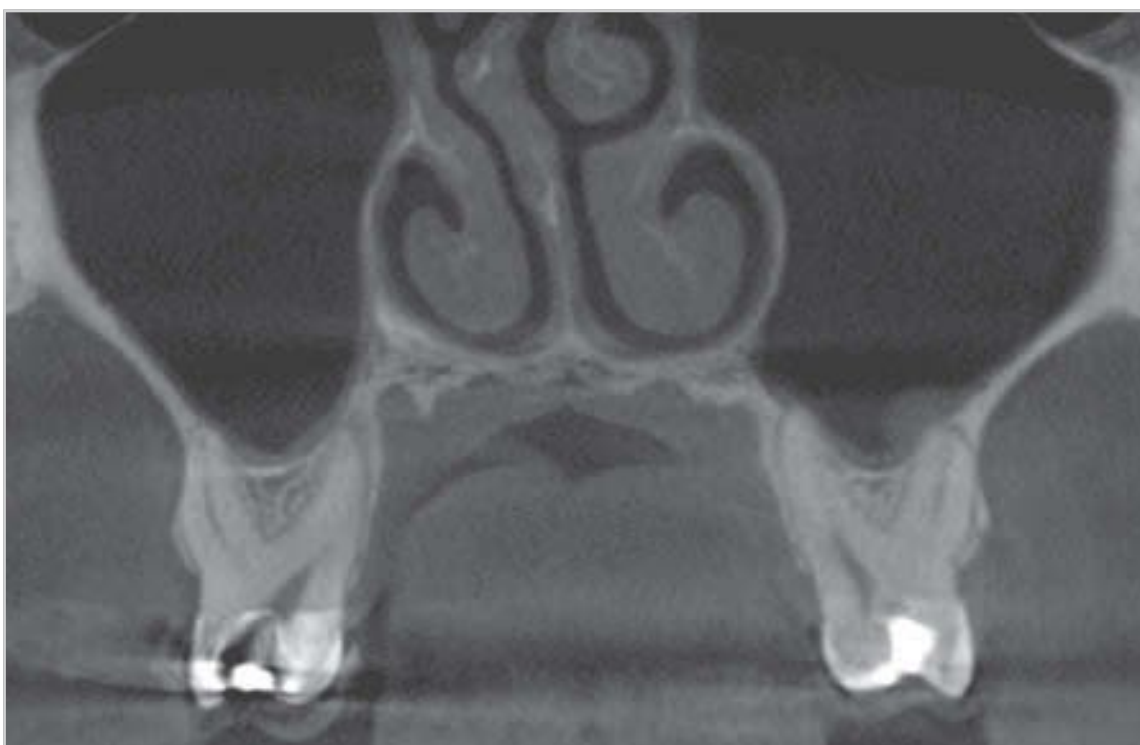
In contrast to the classical orthopantomogram, views of the maxillary sinus can also be reconstructed from the dataset.
